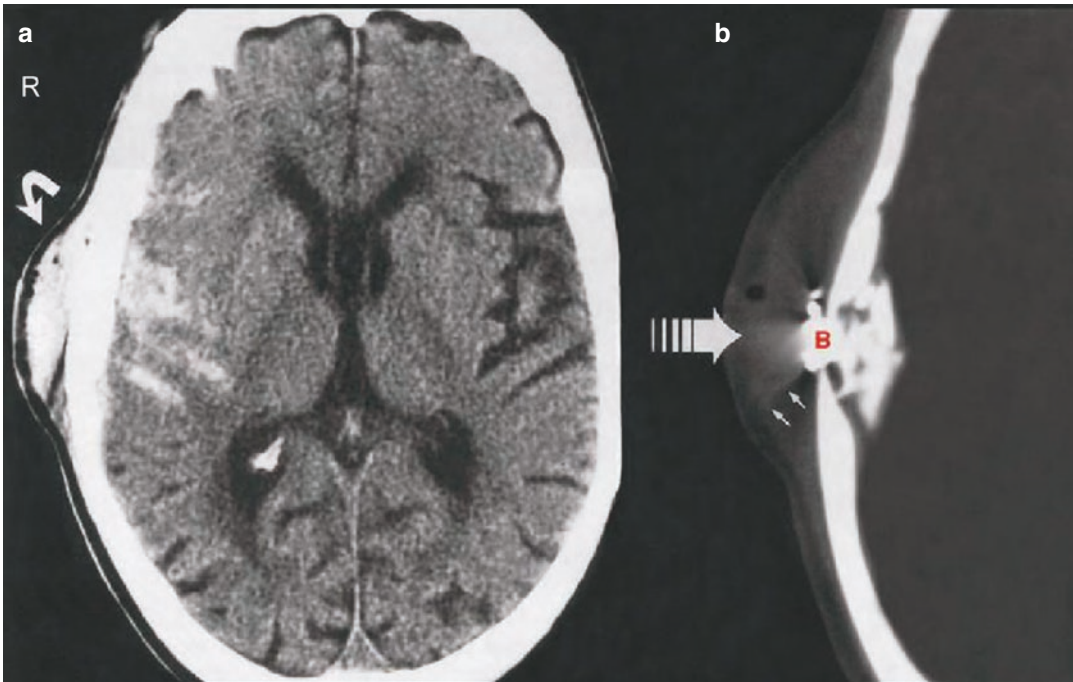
Depressed missile injury. (a) Non-contrast axial CT image demonstrates posterior right temporal scalp soft tissue swelling (*curved arrow*) and a subjacent temporal contusion, subarachnoid hemorrhage, and effacement of the frontotemporal sulci. (b) CT image displayed in bone
